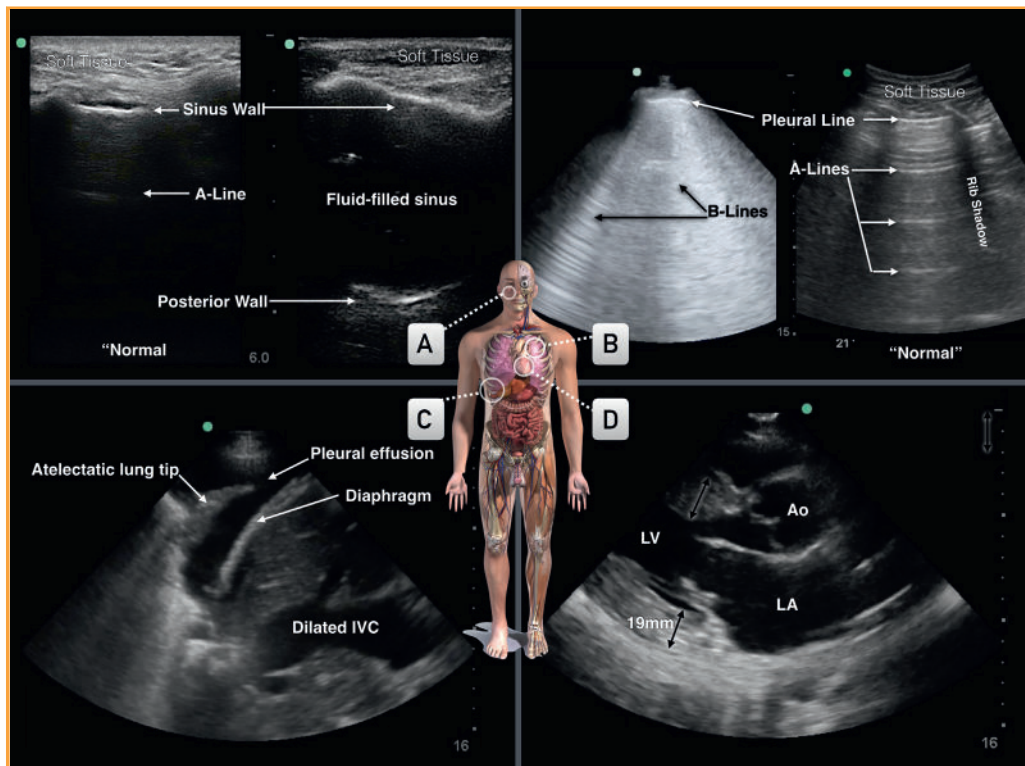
Case 1. Point-of-care ultrasonographic images. A, Normal maxillary sinus (left) compared with abnormal, fluid-filled maxillary sinus (right). B, Pulmonary images showing normal lung (right) and abnormal lung with pulmonary edema (left). C, View at the level of the right diaphragm with pleural effusion and dilated inferior vena cava (IVC). D, Parasternal long-axis view of the heart showing thickened left ventricular (LV) walls, left atrium (LA), and ascending aorta (Ao).
